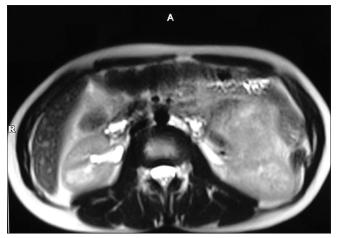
Magnetic resonance imaging showing left adrenal mass lesion
